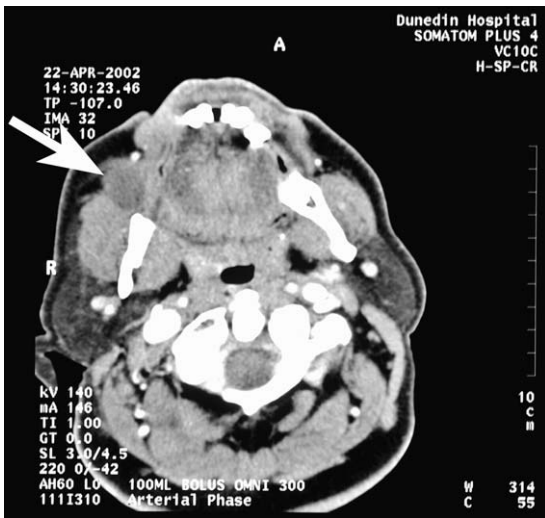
CT scan showing the well-demarcated lesion lying on the lateral aspect of the right buccinator muscle.
